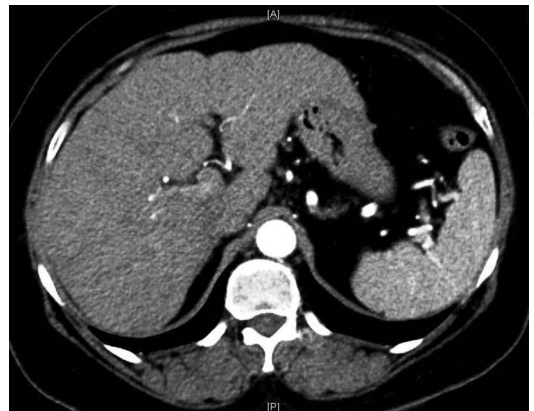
A follow-up CT scan after starting treatment showing reduction in size of hepatic lesions and resolution of splenomegaly.
